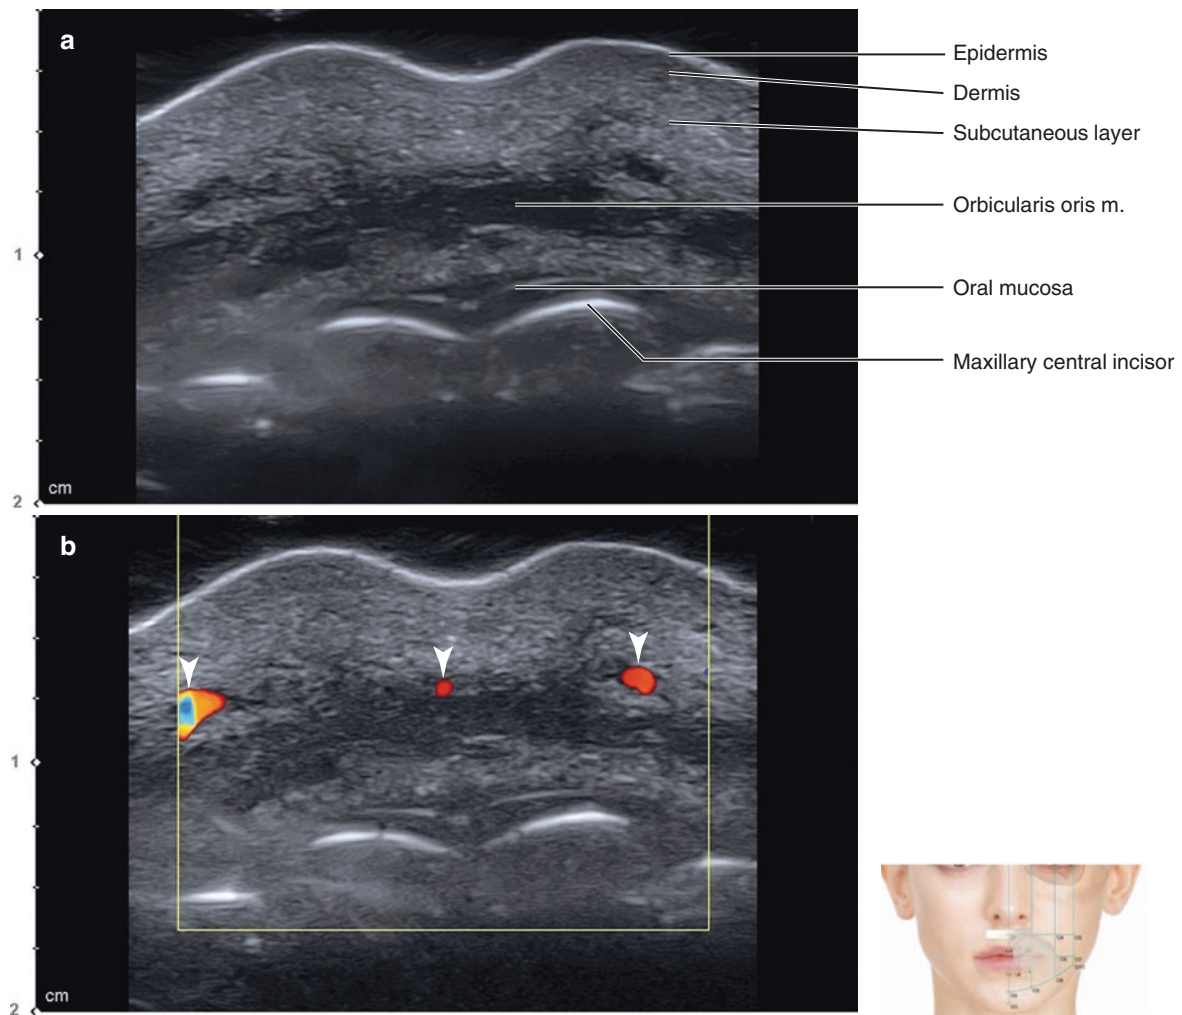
Ultrasonography on the midpoint between subnasale and lowest point of Cupid's bow (O1). (a) B mode (transverse view, 15 MHz by linear transducer) and (b) Doppler mode (transverse view, 15 MHz
